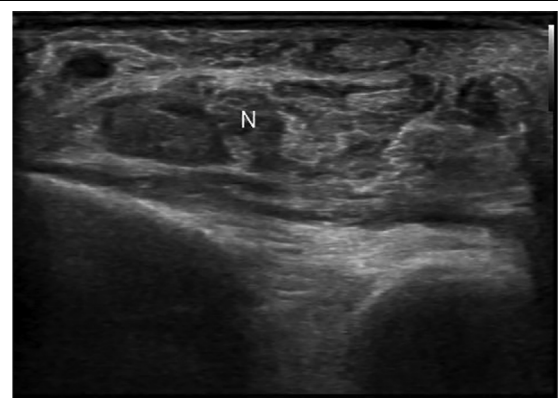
Ultrasonic image of wrist showing no recurrence of the median nerve ("N") compression or synovitis at the level of wrist joint.
